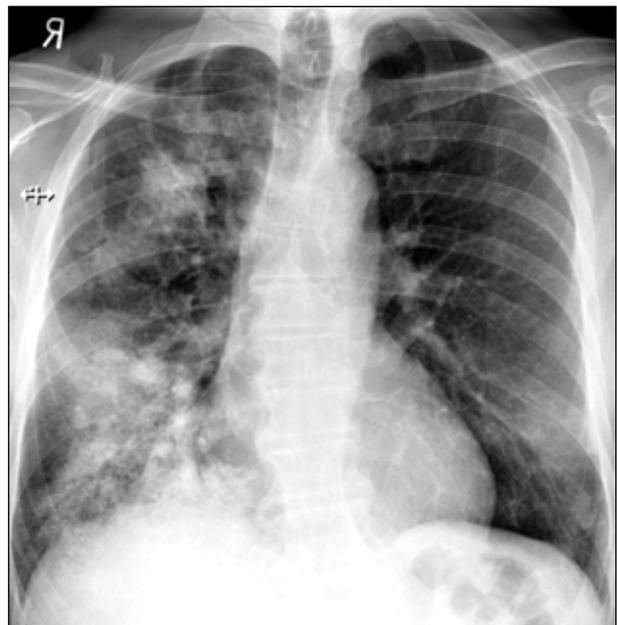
Chest radiograph demonstrating right middle zone opacification and right upper zone infiltrates
